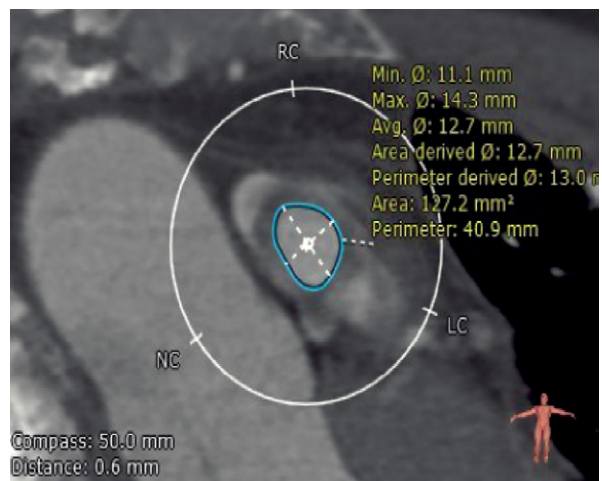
Computed tomographic angiogram shows the sizing of the pulmonary valve.
